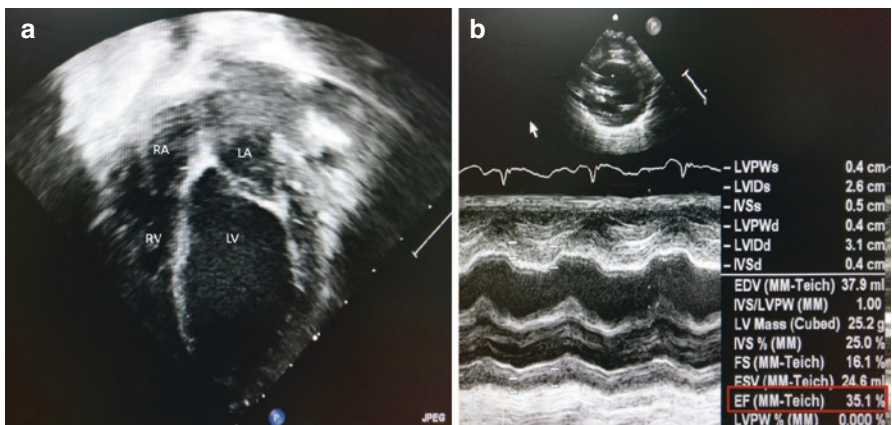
(a) Echocardiogram (apical four-chamber view) of a 9-month old infant showing dilated (and dysfunctional) left ventricle due to vitamin D deficiency. (b) M-mode of the same patient showing reduced left ventricular systolic function (left ventricular ejection fraction—35%)
